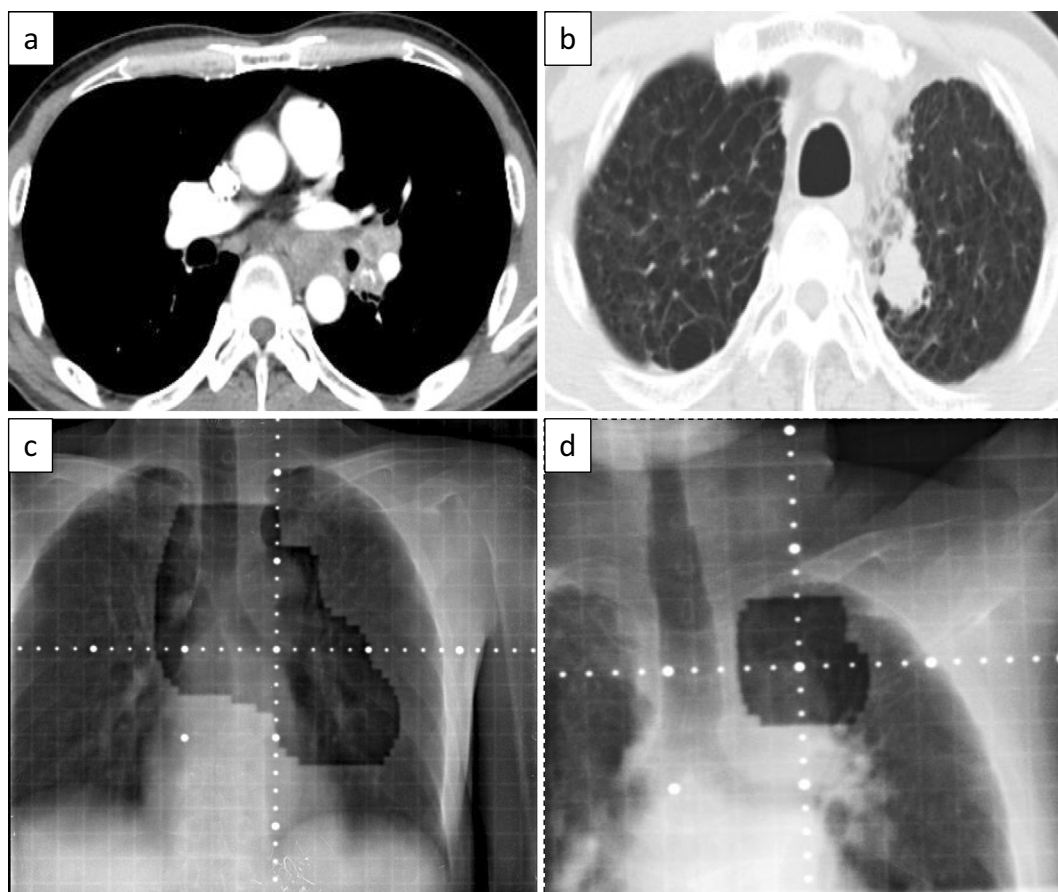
a: Chest computed tomography seven years prior to the admission showed enlarged mediastinal and hilar lymph nodes. b: Chest computed tomography three years prior to the admission showed a tumor in the left upper lobe S¹⁺². c, d: Chest X-ray shows the radiation field of stereotactic irradiation for each treatment.
